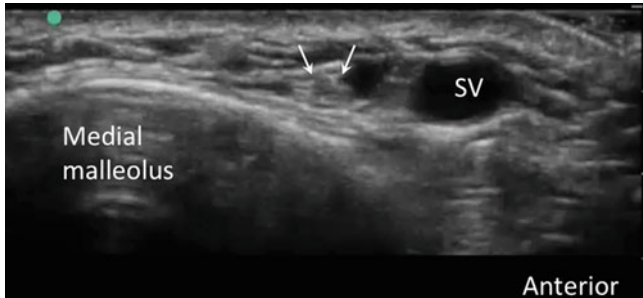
Sonography of the saphenous nerve (*line arrows*). It lies within the same fascia plane with the greater saphenous vein (Reproduced with permission from Philip Peng Educational Series)
